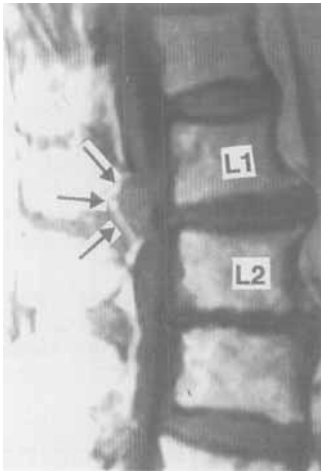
Magnetic resonance imaging exhibits an oval lesion at the L1–2 level.
